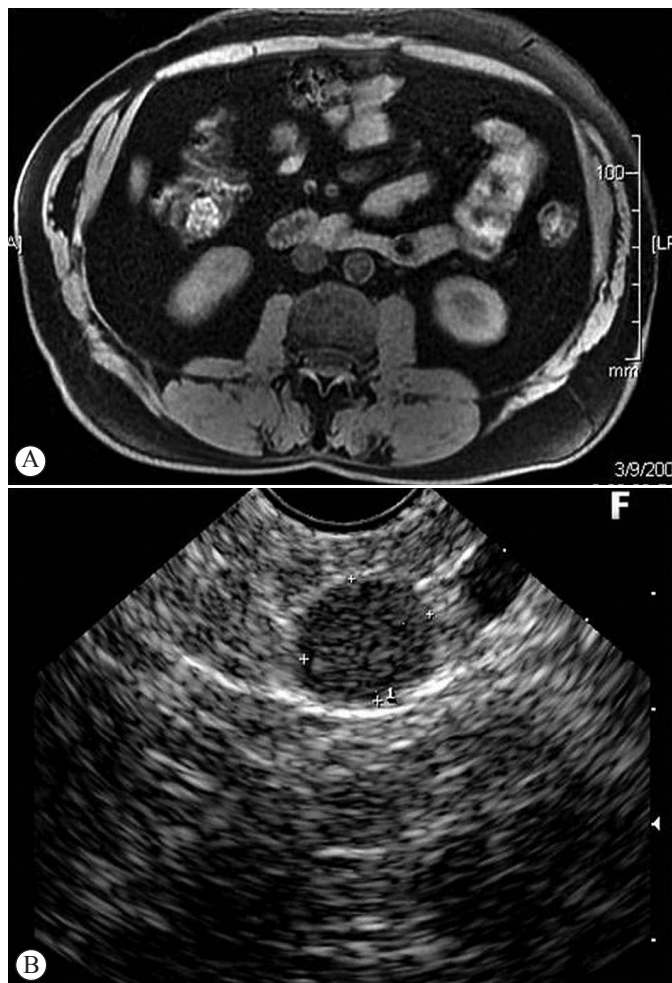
Asymptomatic patient (no. 2) with (a) MRI showing an isolated and hypointense nodule in the pancreatic body. EUS reveals a round, hypoechoic, homogeneous, and regular nodule with well-defined borders, measuring 1.2 x 1.0 cm. EUS was suspicious for NET and FNA was not performed. Surgical diagnosis was PS
